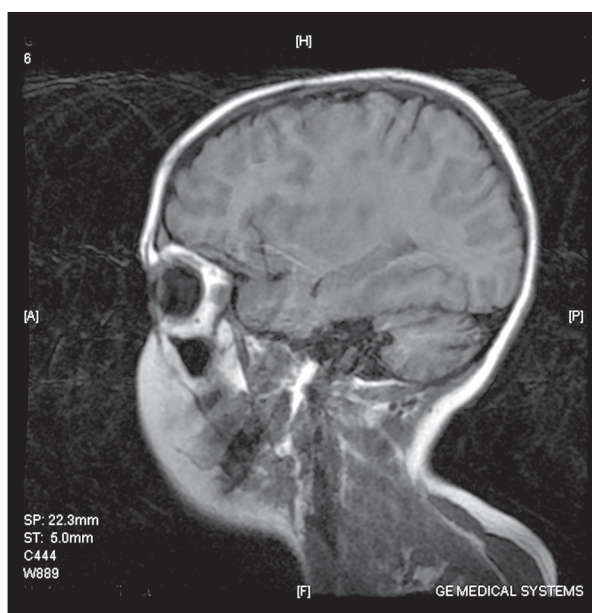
MRI scan of the brain demonstrated cerebellar atrophy and pansinusitis.
